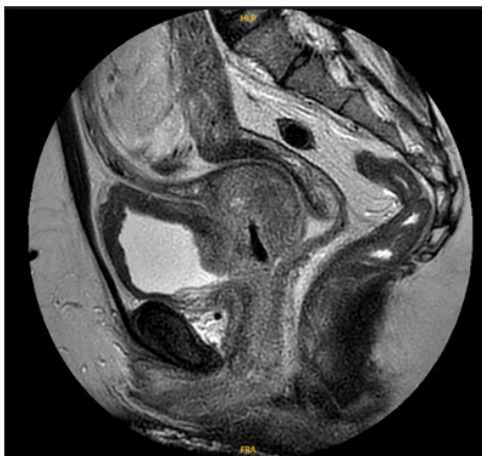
Sagittal view of MRI scan
